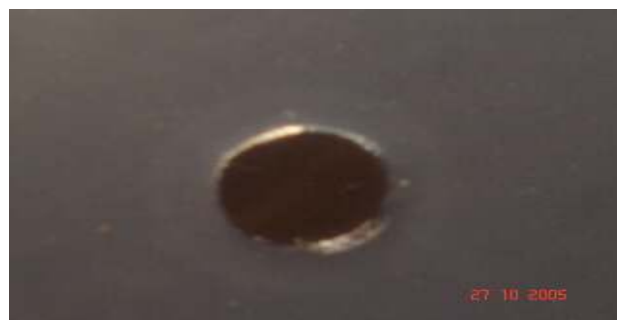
Precipitating ring between purified CT and antiserum in Radial Immune Diffusion test
